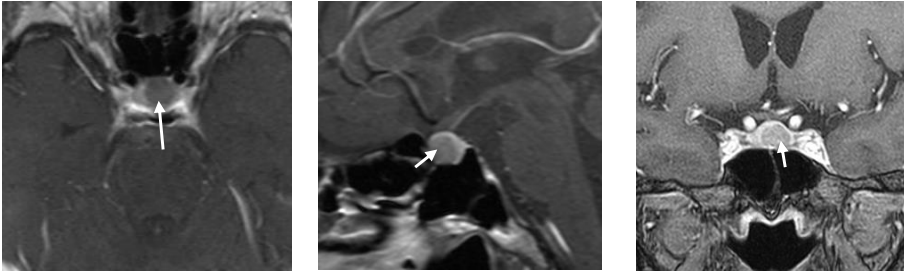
Pre operation MRI showed KNOSP grade 1 of pituitary adenoma (arrow) with maximal diameter 15 mm.
